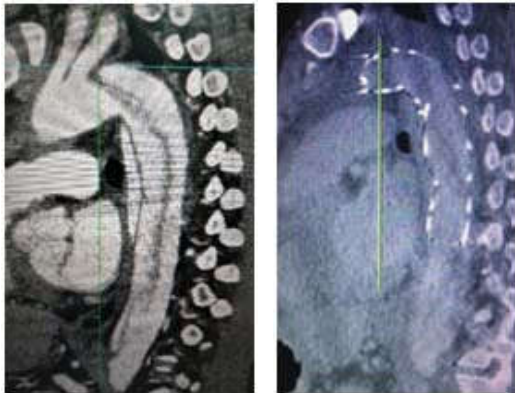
CT aortogram Type B aortic dissection.
